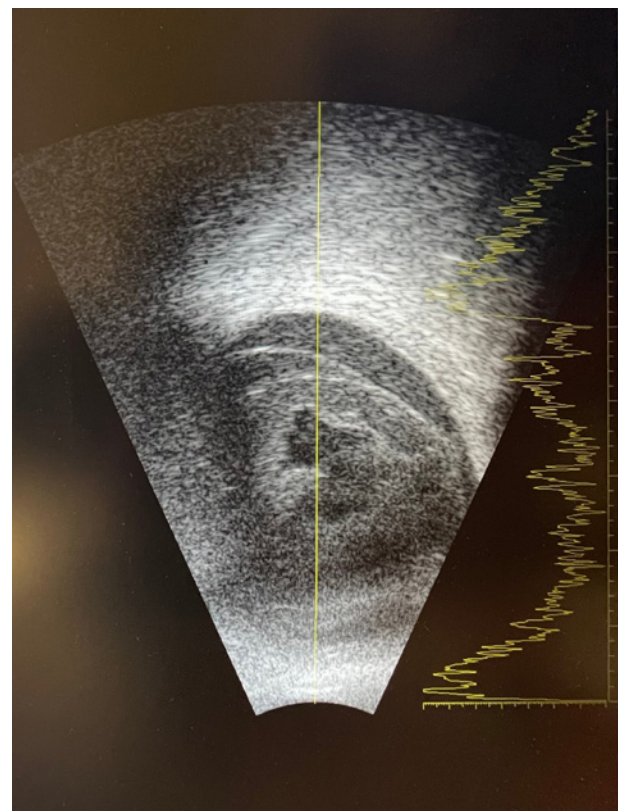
Ultrasound findings in the right eye
